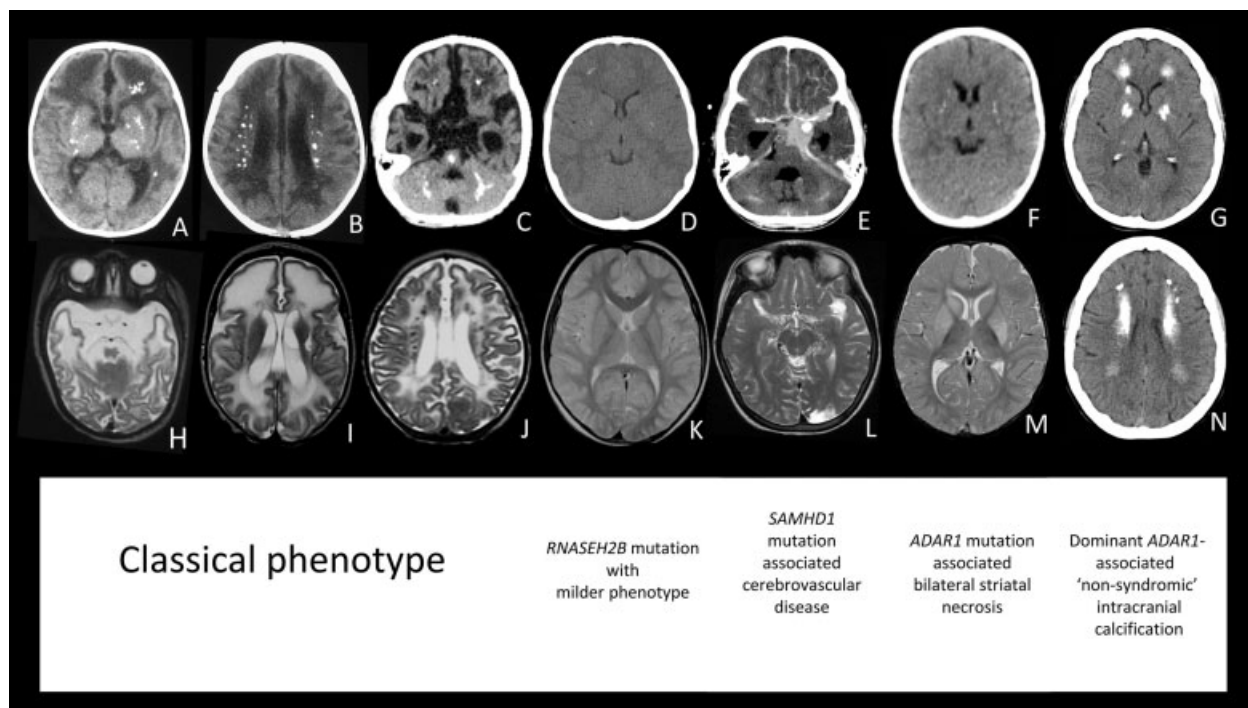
Imaging features associated with mutations in Aicardi–Goutières syndrome (AGS) related genes. (A–C) Computed tomography (CT) and (H–J) T2 magnetic resonance (MR) images of the classical AGS phenotype demonstrating (A, B) spot calcification of basal ganglia, thalami, and deep white matter and (C) calcification of pons and cerebellum. (H, I) Abnormal white matter with swelling of anterior temporal and frontal lobes. Also note the characteristic pattern of atrophy involving the anterior temporal lobes. Calcification is apparent on the (J) T2 MR image as low signal spots within the deep white matter. (D) CT and (K) MR image of a patient with a milder phenotype associated with *RNASEH2B* mutations showing subtle spot calcification in the putamen and deep frontal cortex (D) and normal MR appearances (K). Large cerebral artery disease is particularly associated with *SAMHD1* mutations. (E) CT showing a subarachnoid hemorrhage and a large aneurysm of the left carotid artery. (L) MR image from a different patient shows old ischemic damage in the left occipital region and extensive moyamoya type basal neovascularization. (F) CT and (M) MR image of a patient with *ADAR1* mutation-associated bilateral striatal necrosis. The CT shows bilateral calcification in the putamen. The T2 MR image shows bilateral high signal and swelling in the caudate and putamen. (G, N) Widespread deep white matter and basal ganglia calcification is demonstrated in these CT images from a mildly symptomatic adult harboring a dominant *ADAR1* mutation. Her son, carrying the same dominant mutation (p.G1007R), has a typical AGS phenotype.
